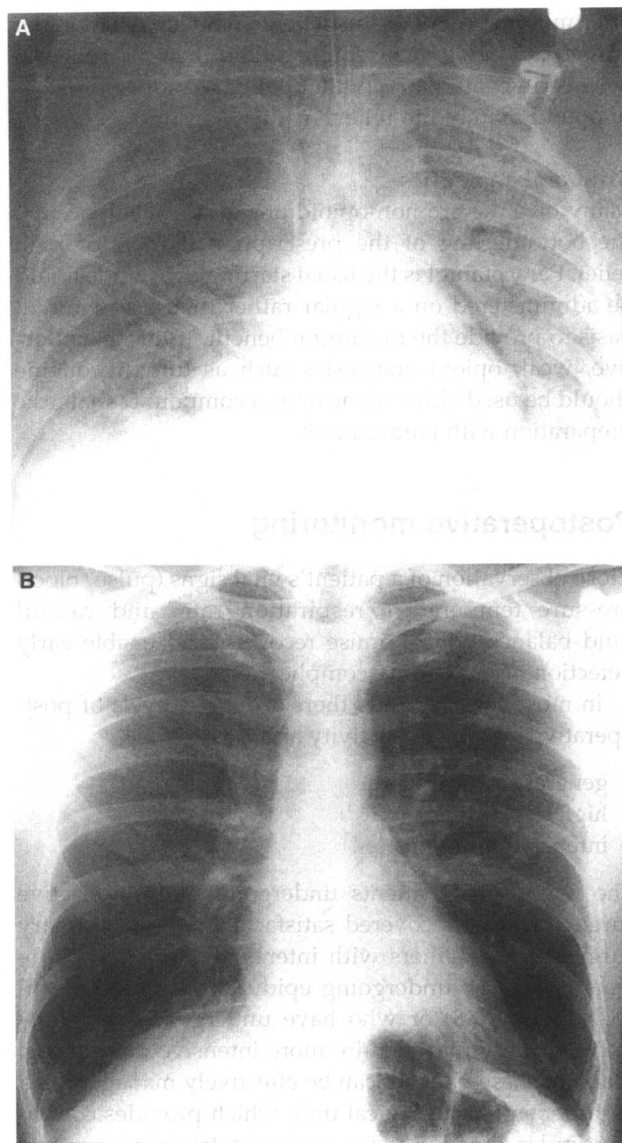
Adult respiratory distress syndrome (A); and a normal chest X-ray (B) for comparison.
